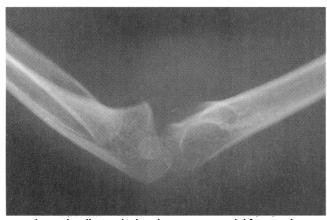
Lateral radiograph showing a supracondyl fracture in a child—the anteroposterior view appeared normal. There is a large joint effusion with positive anterior and posterior fat pad signs. Minimal cortical disruption is seen on the posterior aspect of the lower humerus but there is posterior displacement of the distal fragment with the anterior humeral line passing anterior to the capitellum.
